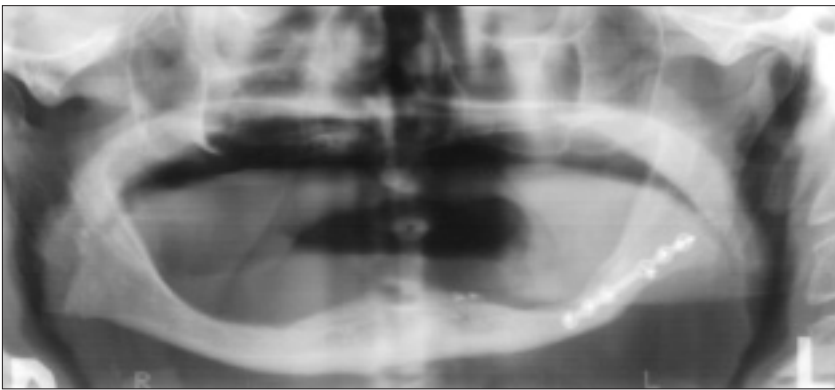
Panoramic radiograph of the patient 1 year later confirms good bone healing.
